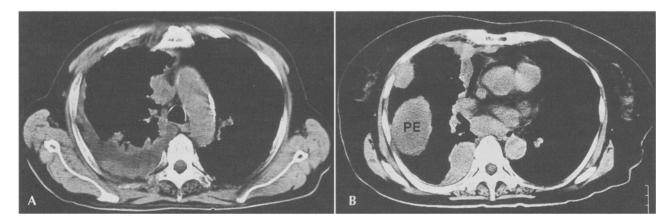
CT scans of the chest showing dissemination of tumor to the right pleura: (A) case 1; (B) case 2. Encapsulated interlobar pleural effusion (PE) was also present in case 2.
